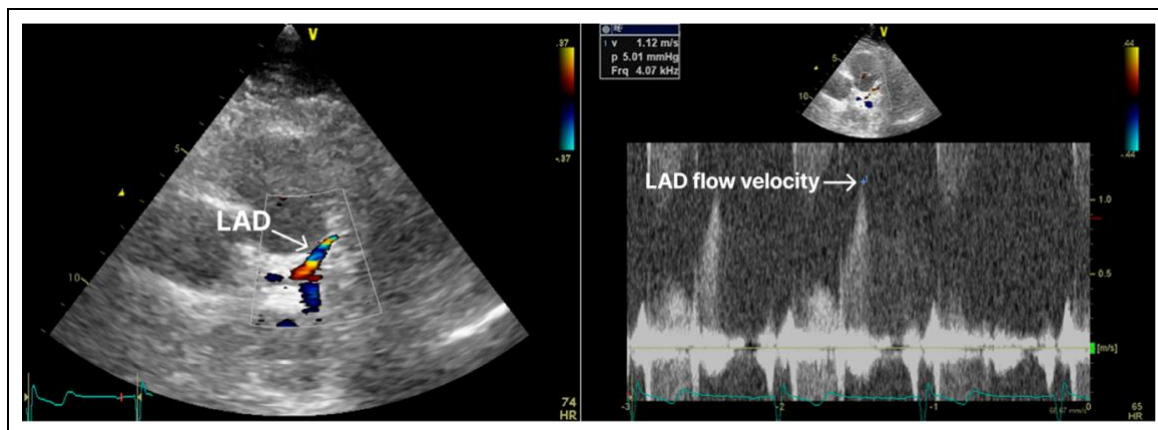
Transthoracic Doppler echocardiography of the left anterior descending artery in Case 1: Color Doppler imaging demonstrates the left anterior descending artery (LAD) in the proximal segment. Pulsed-wave Doppler recording shows increased resting diastolic coronary flow velocity, consistent with hemodynamically significant LAD stenosis.
